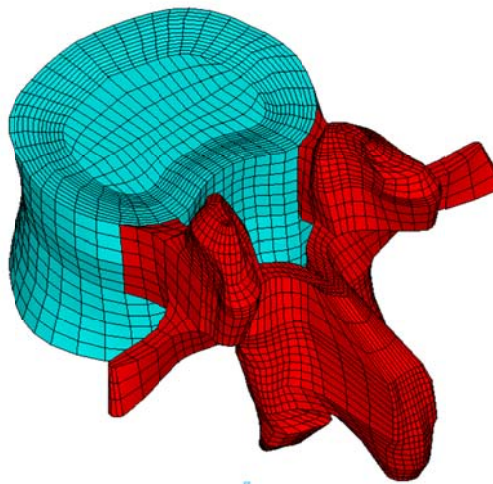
Each spinal component was selected from computed tomography scan DICOM file to create material-related contours.
